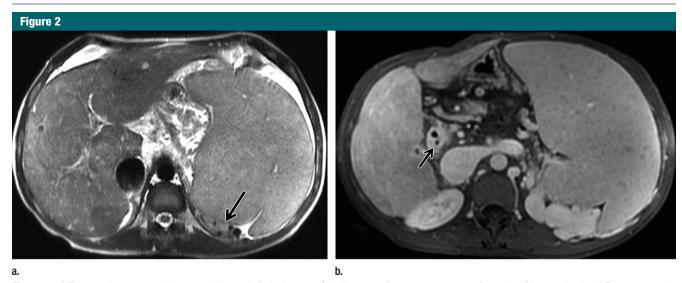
MR images in a 27-year-old woman with morphologic changes of the liver secondary to cavernous transformation of the portal vein. (a) Fat-suppressed fast spin-echo (SE) T2-weighted image (repetition time msec/echo time msec, 2500–8000/90; flip angle, 90°; section thickness, 4 mm) shows central liver hypertrophy (segment 4 and caudate lobe), peripheral atrophy, and signs of portal hypertension (splenomegaly and portocaval collaterals [arrow]). (b) Contrast-enhanced gradient-echo (GRE) T1-weighted image (4.5/2.2; flip angle, 10°; section thickness, 4 mm) at the portal venous phase demonstrates portal cavernoma around the common bile duct (arrow).
